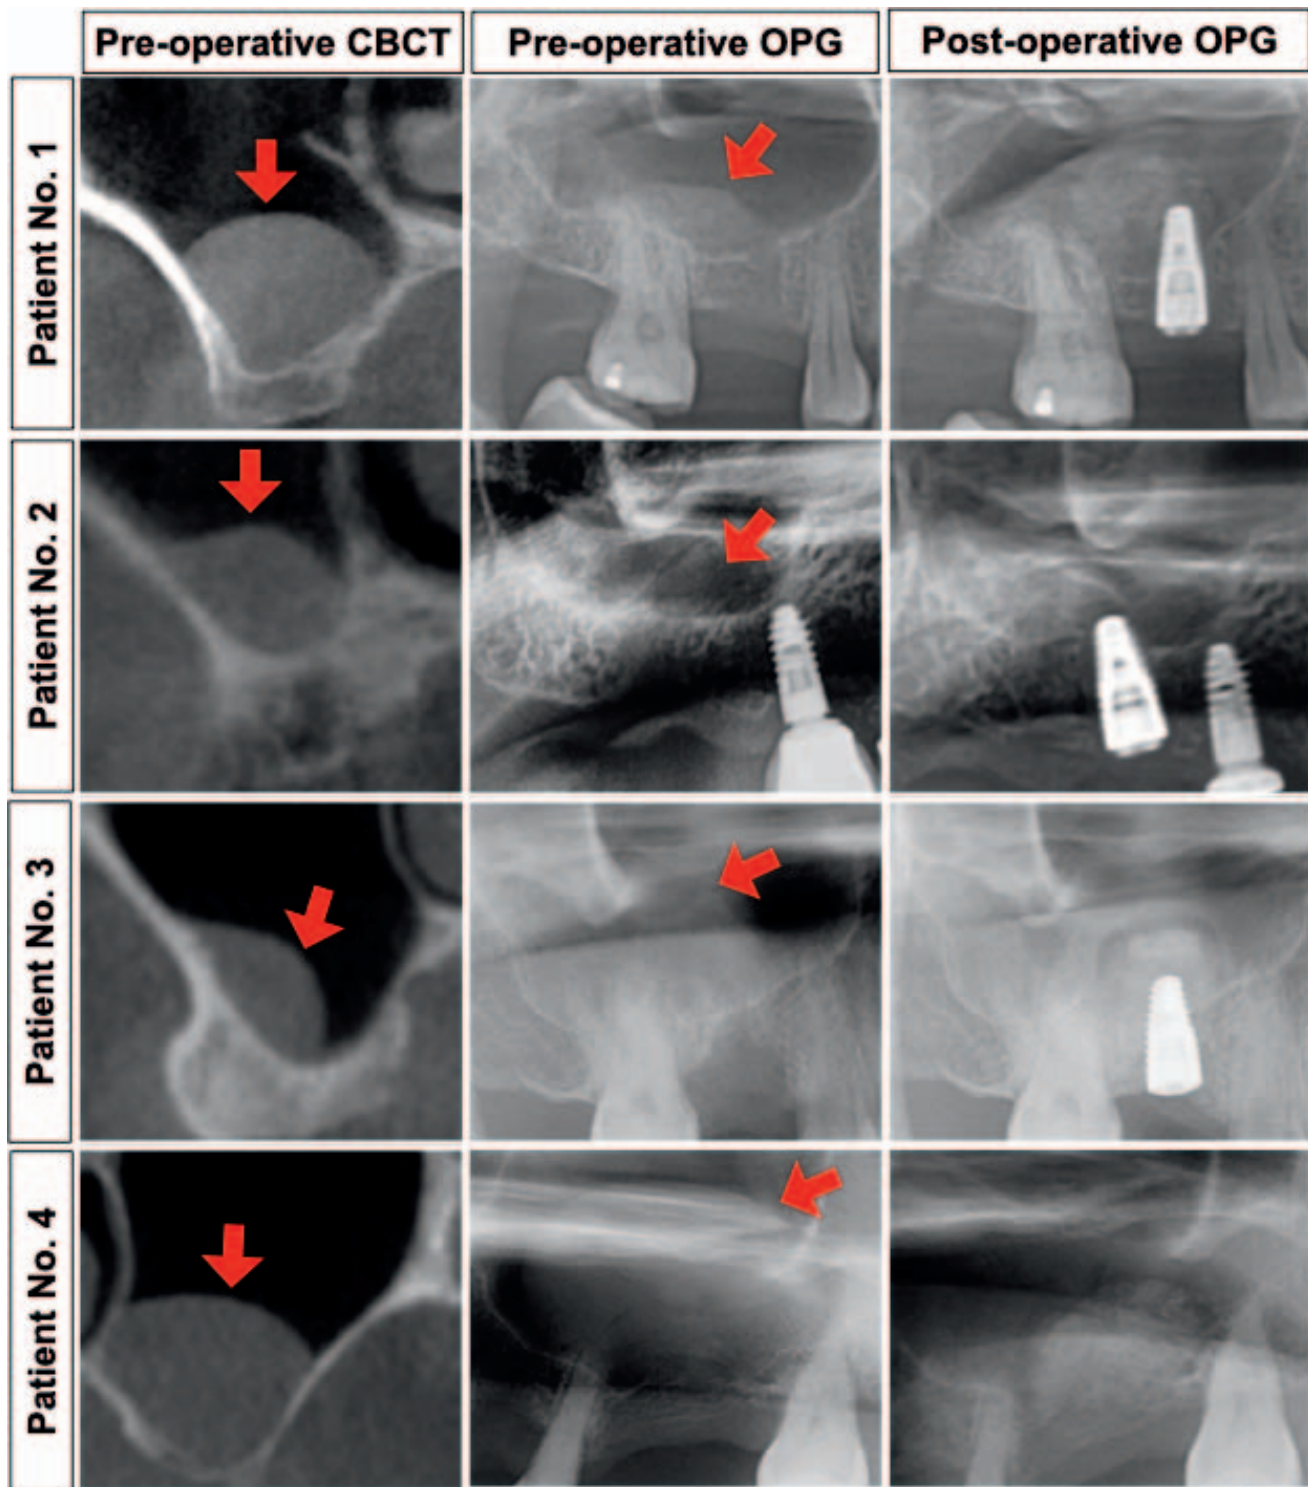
Preoperative CBCT and preoperative and postoperative orthopantomograms of the 4 cases. The red arrows points to the APs.
